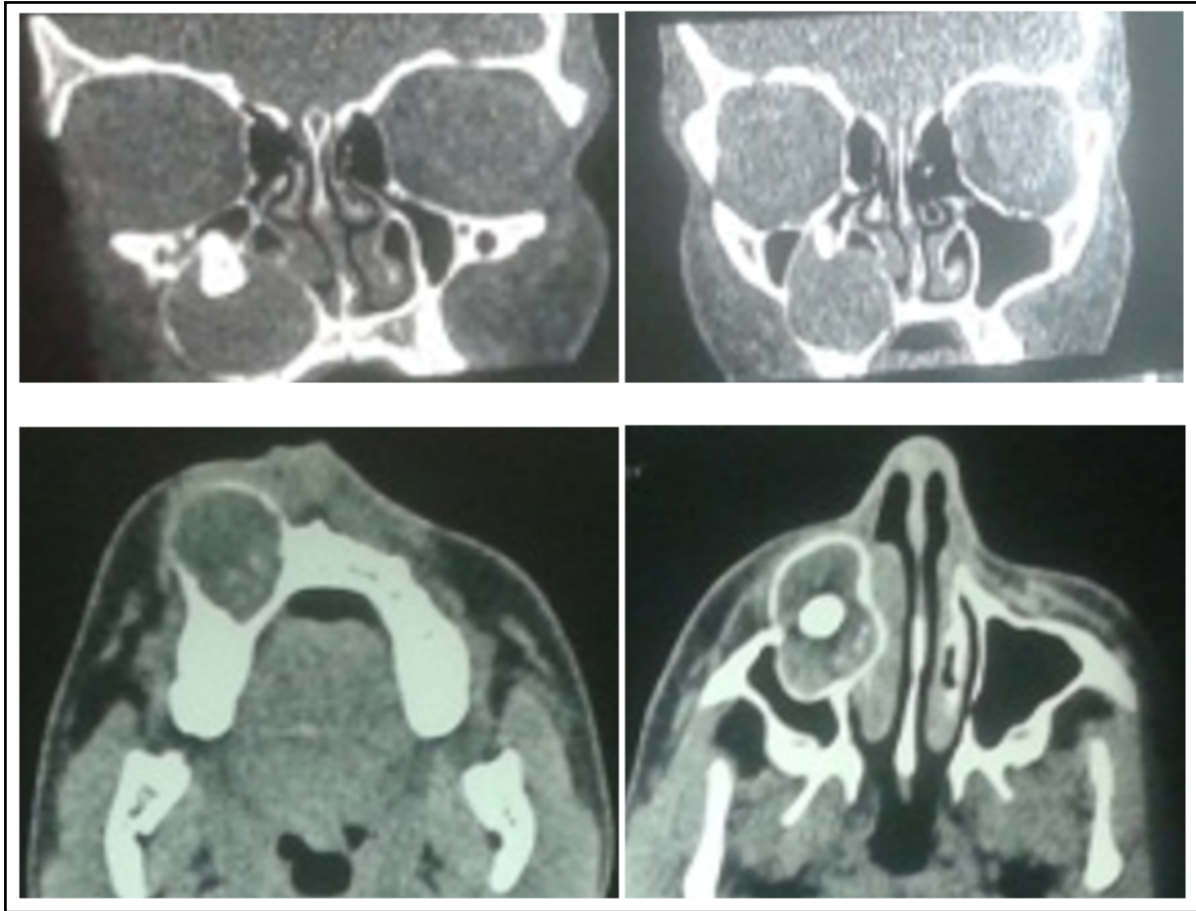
CT scan PNS showing dentigerous cyst with impacted tooth
